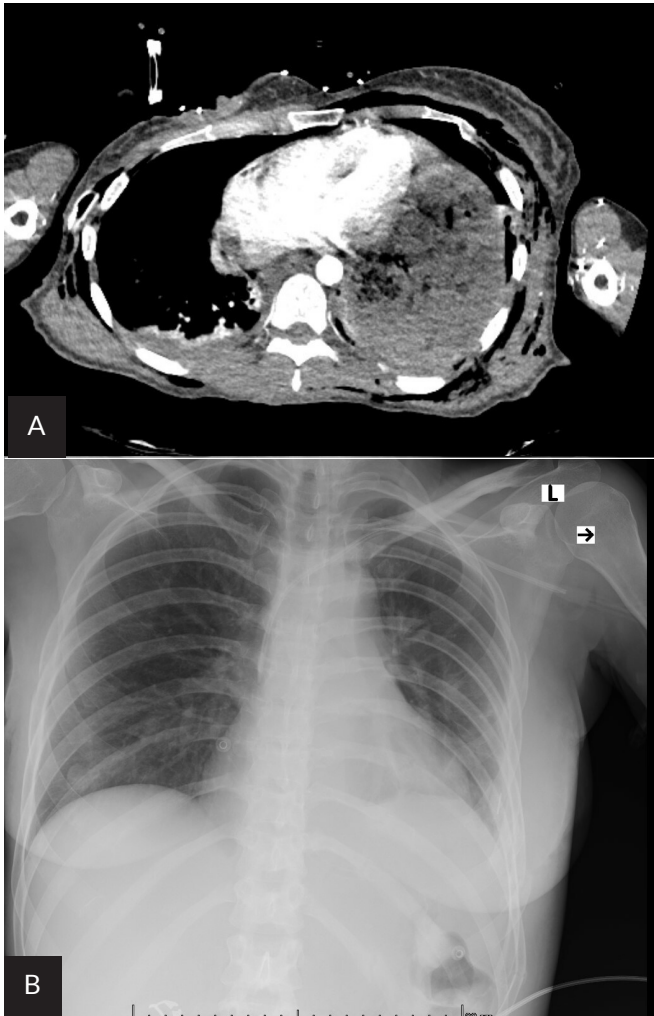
Case 11. A. Preoperative computed tomography. B. Postoperative x-ray
